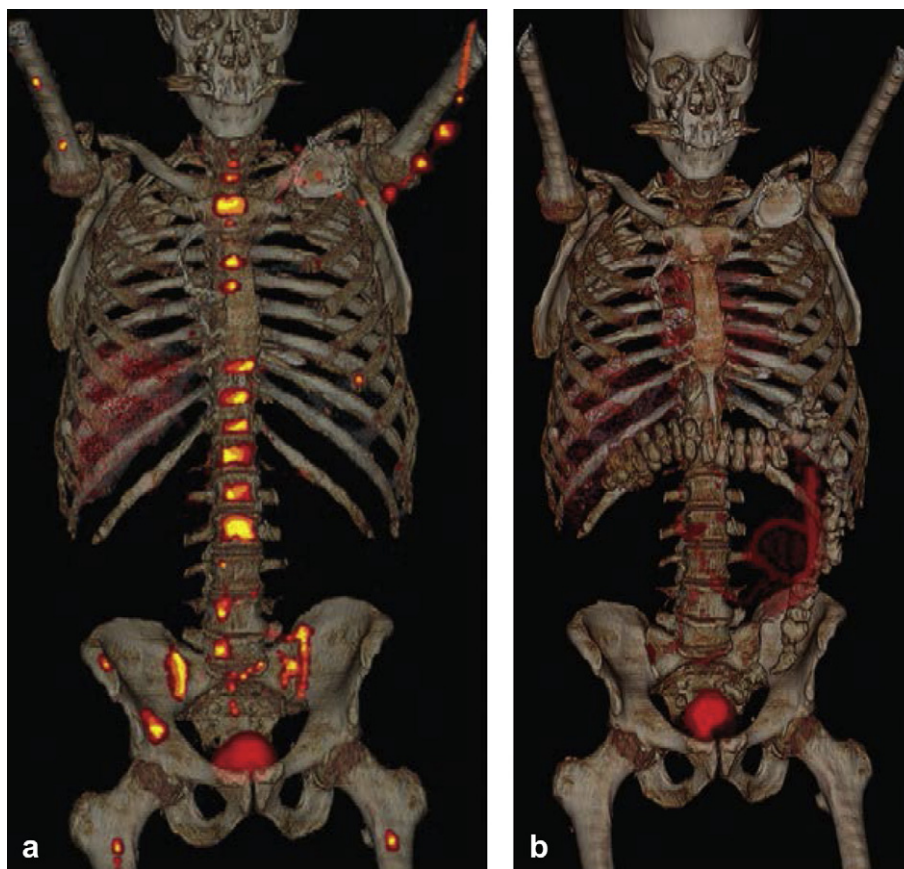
FDHT-PET/CT images in a 69-year-old patient with castrate-resistant metastatic prostate cancer (a) prior to and (b) 4 weeks after treatment with MDV3100, an androgen receptor antagonist. The images show a substantial reduction of FDHT accumulation in widespread bone metastases after 4 weeks of treatment, indicating successful targeting of the androgen receptor by MDV3100. (Reprinted from Hricak H. Oncologic imaging: a guiding hand of personalized cancer care. *Radiology*. 2011 Jun; 259(3):633–640).
